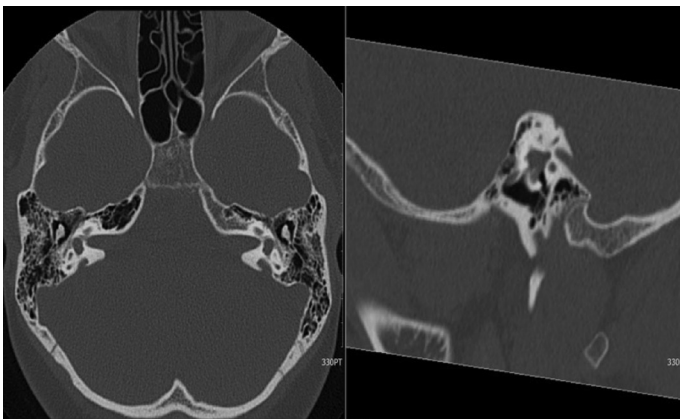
Computed tomography (CT) scan. Presentation of bilateral enlarged vestibular aqueducts in a 11-year old child with an history of bilateral conductive hearing loss. The child did not present any sign of middle-ear disease.
